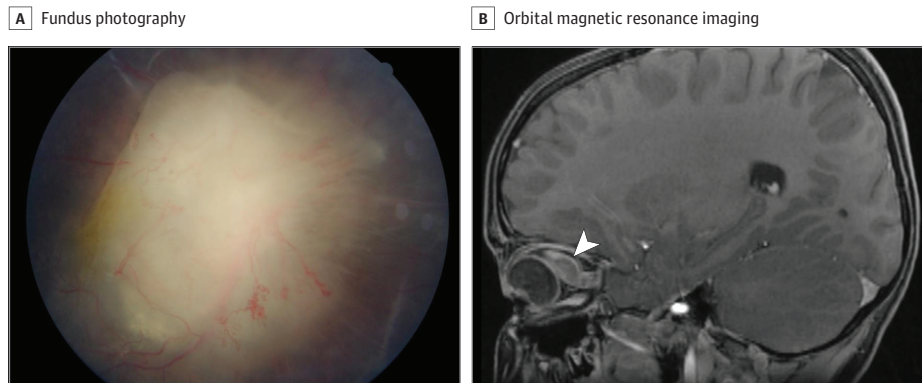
Fundus photography and orbital magnetic resonance imaging (MRI) in a 7-year-old boy referred for right leukocoria. A, Fundus photography shows a white prepapillary mass with intravitreal extension. B, MRI reveals an intraorbital mass (arrowhead) typical of a glioma, pushing on the globe of the eye, resulting in the hypotropia and proptosis found on clinical examination.
